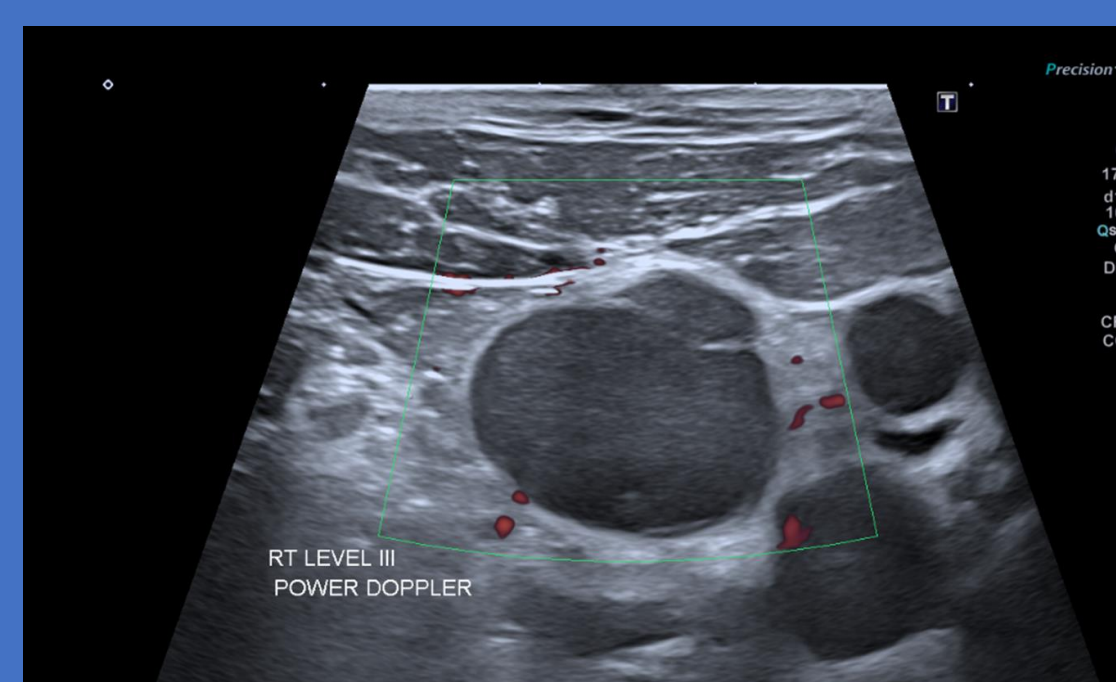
Showing: US Lymph Node with Extracapsular breach note lack of flow on Power Doppler
